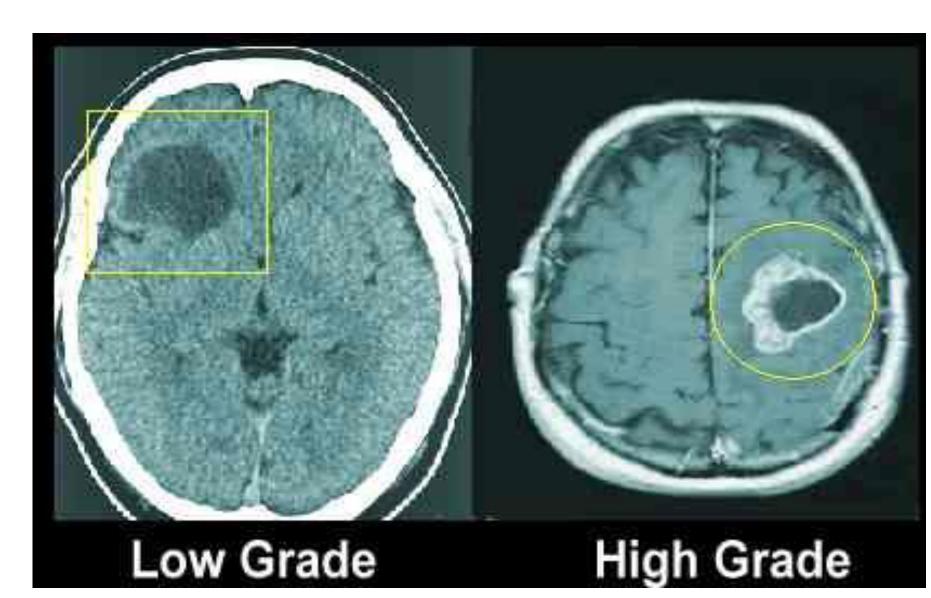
MRI scan of glioma and GBM (http://www.aboutcancer.com/mri_gbm.htm)
